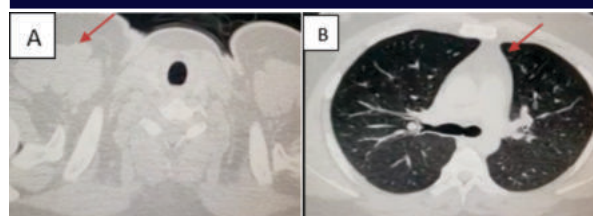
(A & B), Images of CT thorax done before discharge.
